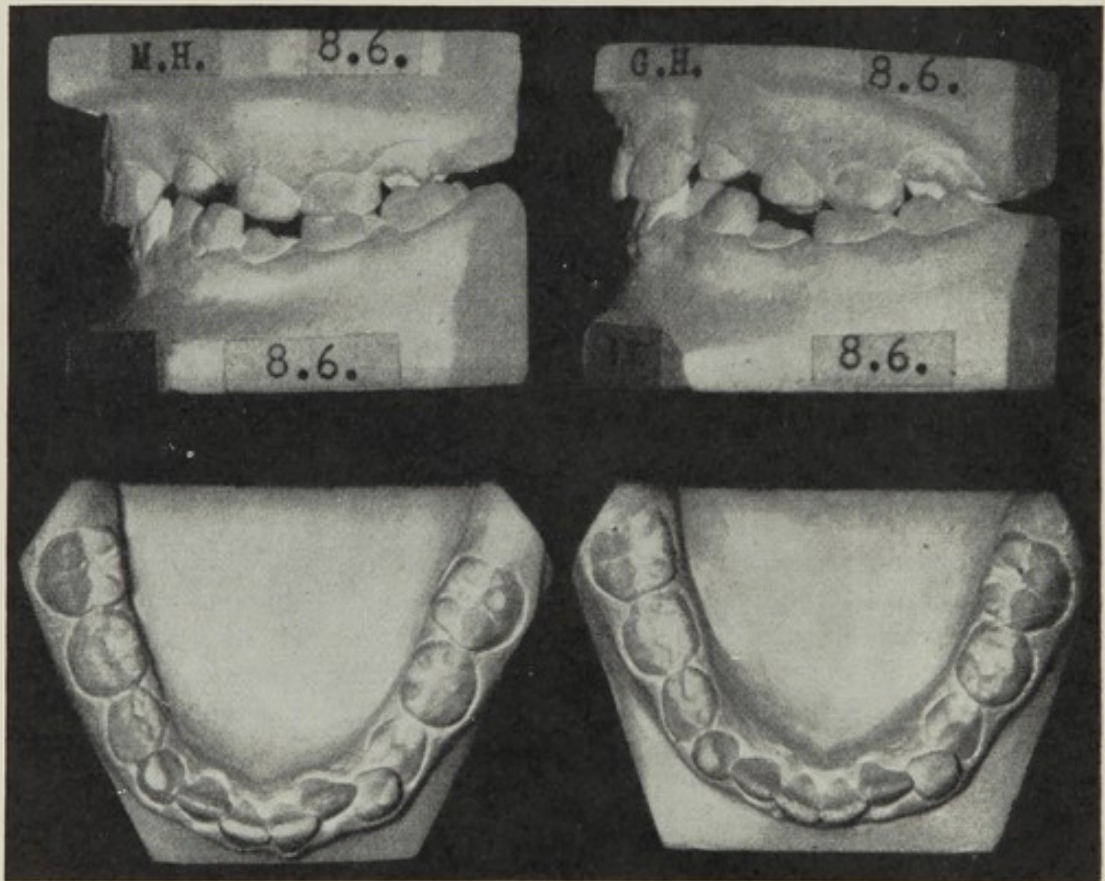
Similarity of development and defects in identical twins. Models from the mouths of two monozygotic twins aged $8\frac{1}{2}$ years. The following special points of resemblance were noted: in both, left upper lateral incisor and first molar are just erupting, the left lower lateral incisor is instanding, and the left lower first deciduous molar is below the plane of occlusion. Radiographs show that both the second upper premolars will be absent in each case. (Photographs by courtesy of the Orthodontic Dept., Dental School, Guy's Hospital, London.)
